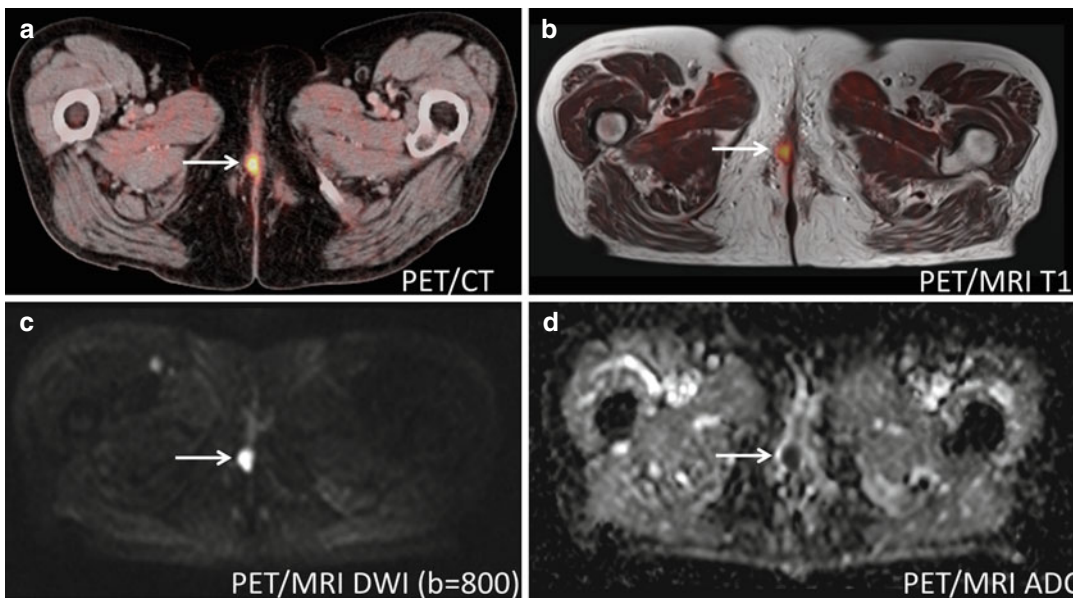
A 73-year-old female with endometrial cancer of the uterus and metastatic spread. FDG-PET for restaging: (a) FDG-PET-CT shows focal accumulation of FDG in the labial region (*arrow*) which could represent either metastatic spread or contamination (activity in the urine).
